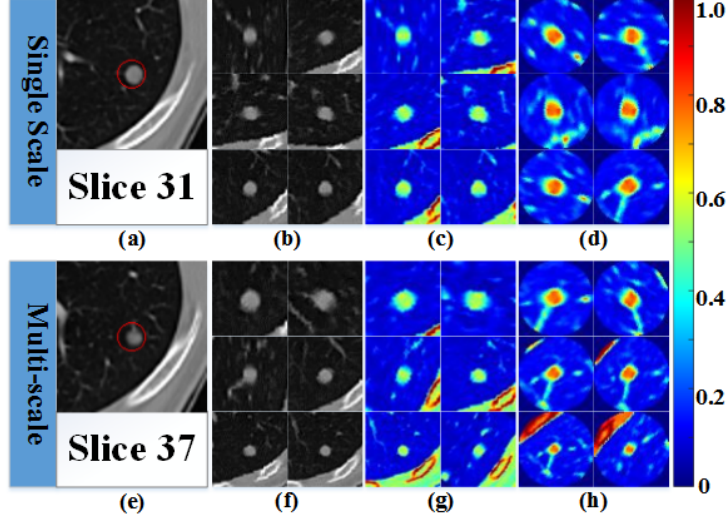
Generated multi-scale inputs for proposed CNNs. (a) and (e): axial view of original CT images on slice 31 and 37. (b) and (f): 2-D images sliced from original volume and CT values compressed to gray-scale images. (c) and (g): same with (b) and (f), but images are re-built using color projections. (d) and (h): re-built images using concentric sampling data and color projection. The color map used is also shown on right.
